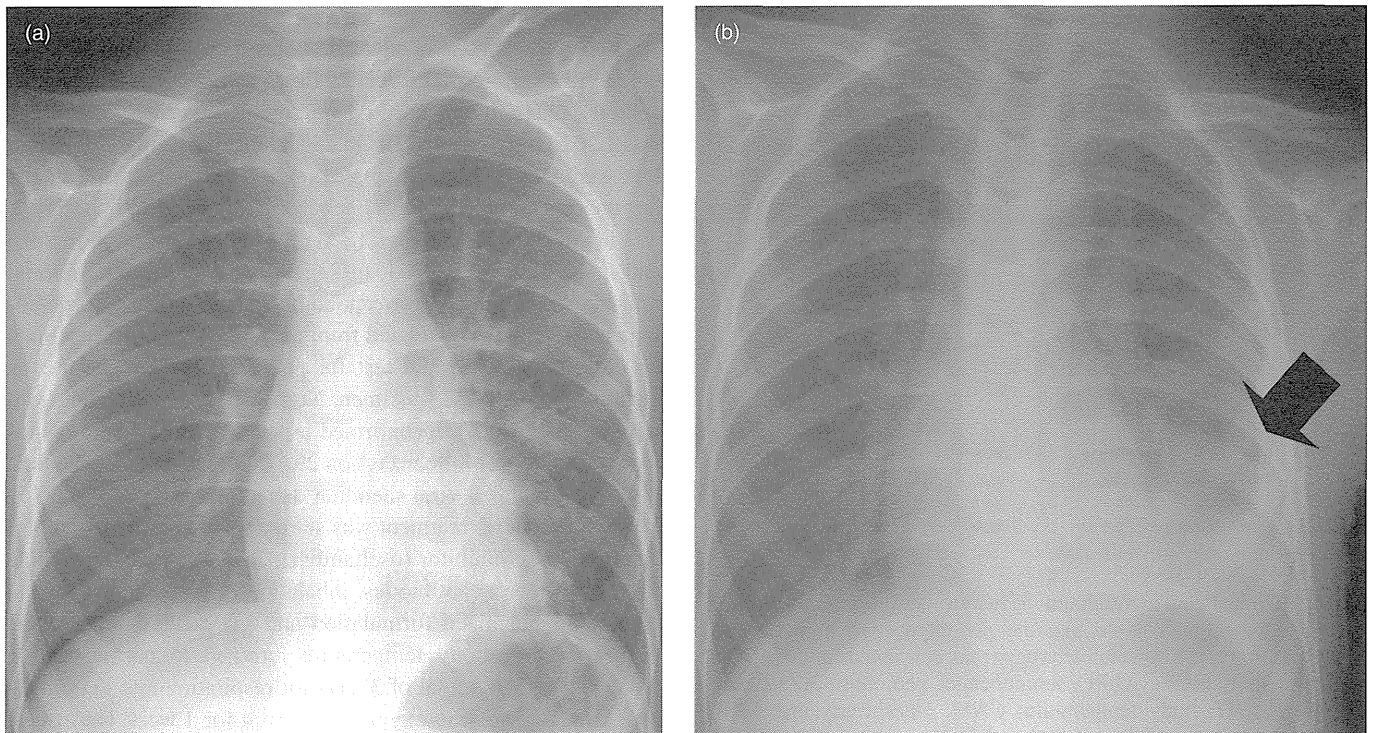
Chest roentgenogram. (a) Bilateral pneumonia is present on admission. (b) On the second hospital day, pneumonia in the left side extended to the lower one-third area with pleural fluid (arrow).
